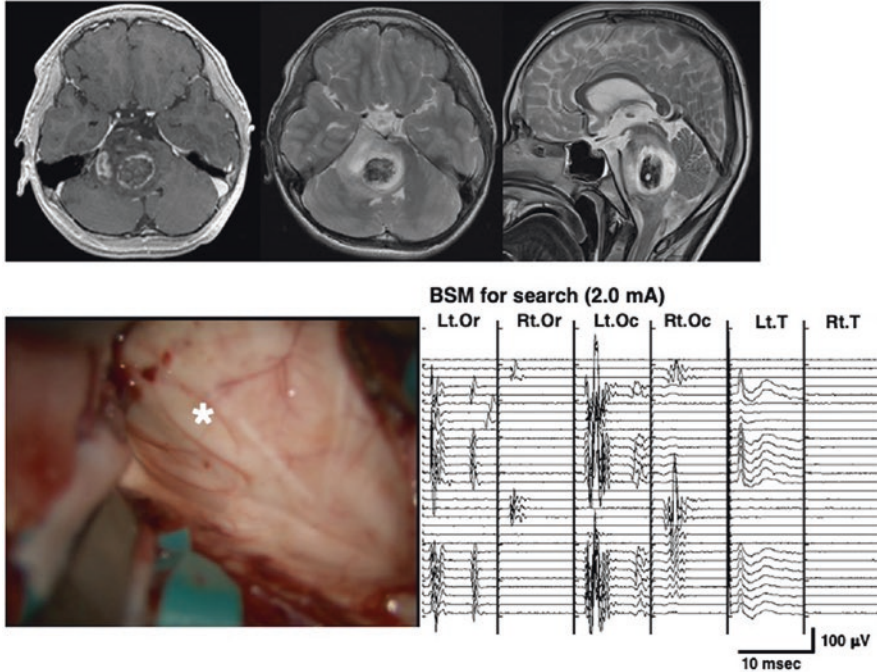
An 11-year-old boy with a diffuse intrinsic pontine glioma and intratumoral hemorrhage. Upper: MRI showed a diffuse intrinsic pontine tumor predominantly located in the right mid-pons with intratumoral hemorrhage. Lower left: An intraoperative photograph of the floor of the fourth ventricle showed bulging of the right side of the floor (asterisk) with a midline shift to the left side. Lower right: BSM using the stimulation intensity of 2.0 mA for a search of the CNMN (*Or* orbicularis oris muscle, *Oc* orbicularis oculi muscle, *T* intrinsic tongue muscle)
